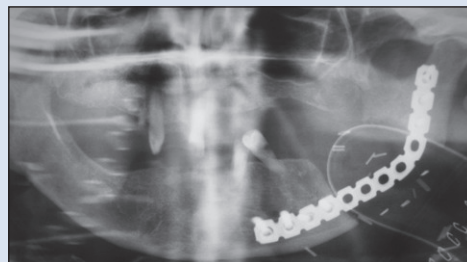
Postoperative orthopantomogram following resection of the left mandibular tumour. A reconstruction plate has been applied to restore jaw rigidity necessary for pain-free movement and mastication.
